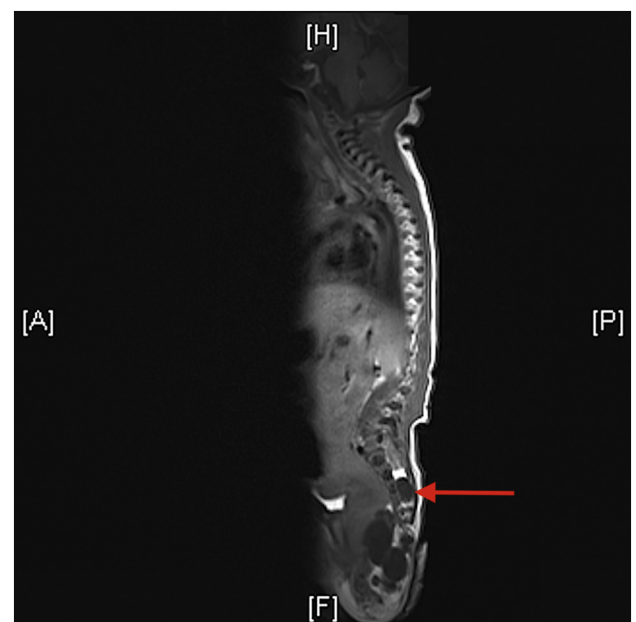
Preoperative sagittal T1-weighted MRI with intraspinal extension marked (red arrow). A = anterior, P = posterior, H = head, F = foot.
